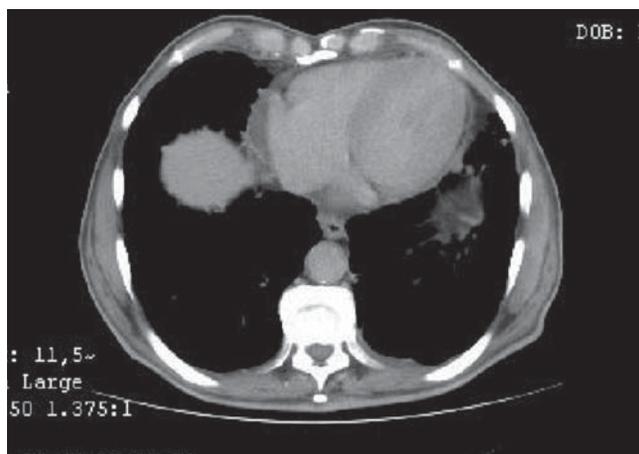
Thoracic CT scan: Tumoral masses in both lungs.
